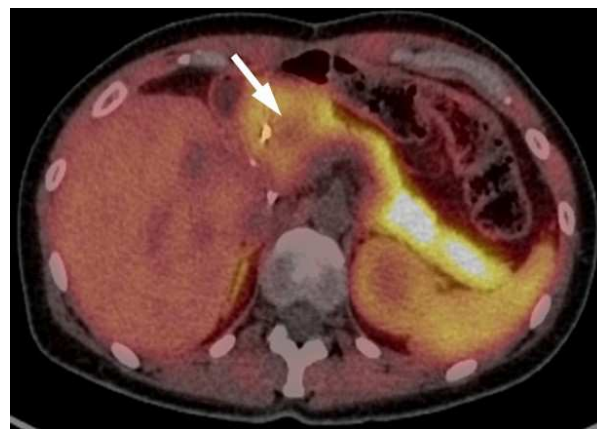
^{11}C -acetate PET/CT scan showing a decreased uptake of the tracer within the pancreatic head (arrow) as compared to the remaining pancreatic tissue suggesting the presence of a pancreatic head tumor.
